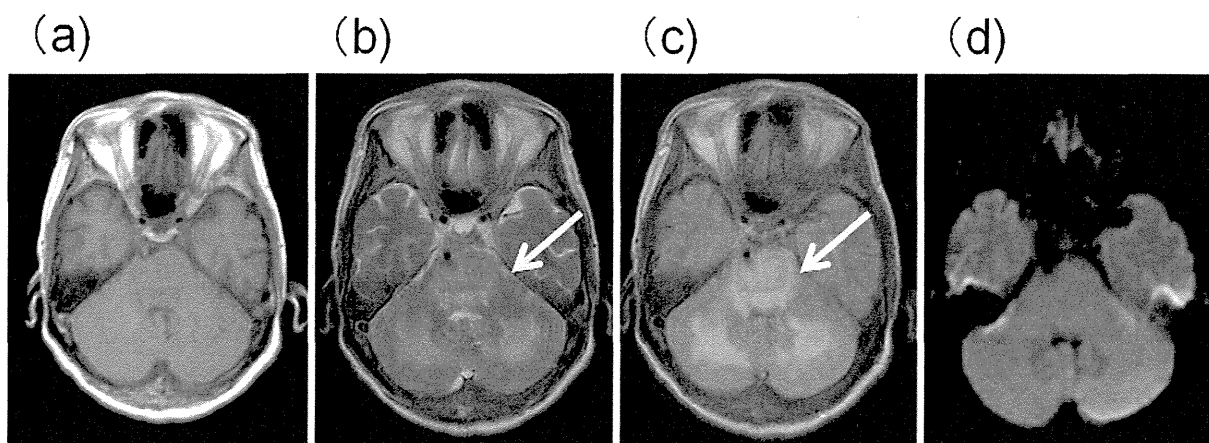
MRI findings of the brain stem and cerebellum upon admission. (a) T1WI. (b, c) T2WI and FLAIR. High intensity signals (arrow) were observed. (d) DWI.
